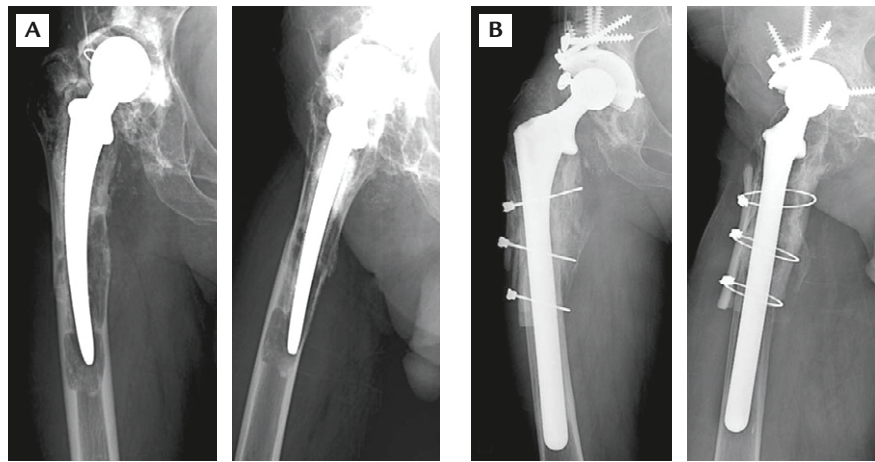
A 76-year-old man received all-cemented total hip arthroplasty 30 years ago. (A) Severe diaphyseal osteolysis with cement–bone loosening was demonstrated by preoperative radiography. (B) Radiography at 30 months after revision surgery with canaloplasty revealed solid union of the osteotomy and good incorporation between the graft and the host bone. The stem achieved good stability.
